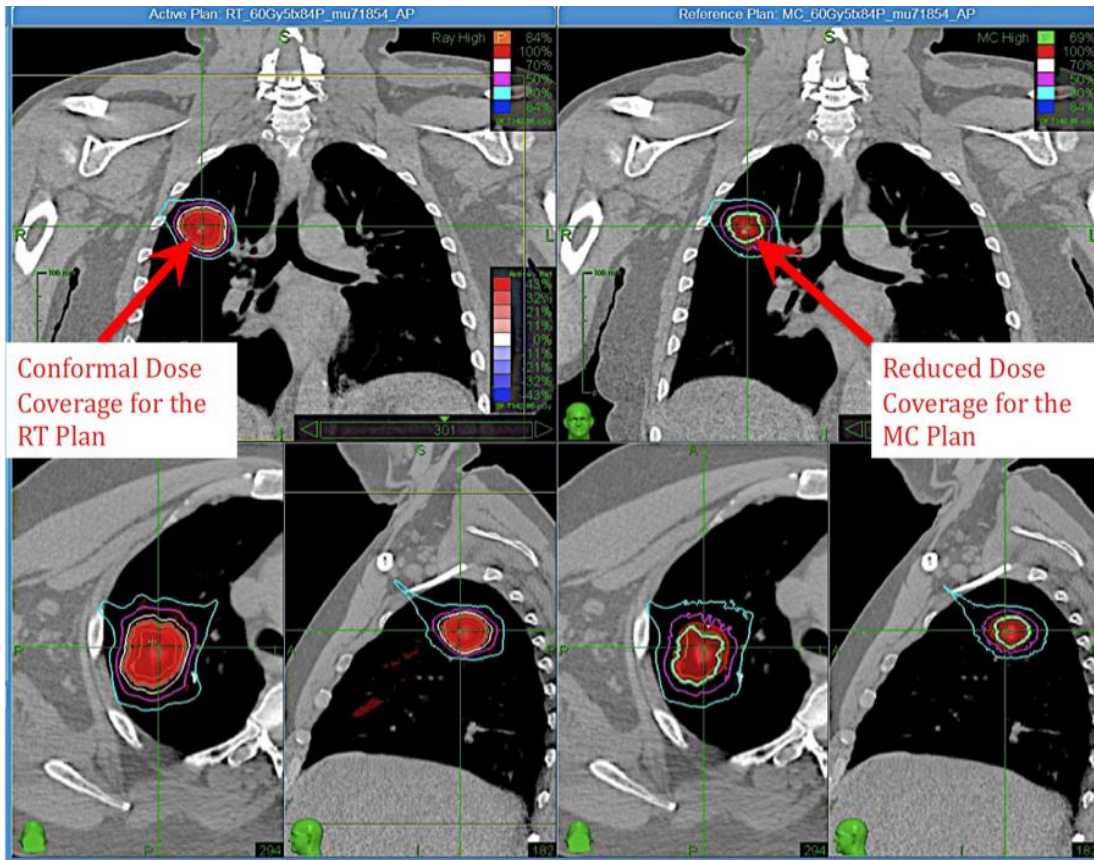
CT-Scan showing differences in PTV between RT and MC calculated plans.
